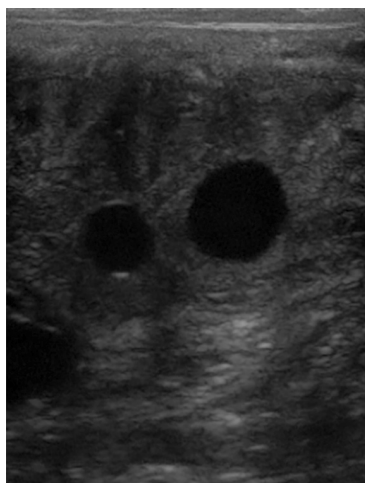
Early detection of twin pregnancy: transrectal ultrasound image showing two vesicles side by side at 14 days post ovulation. One vesicle measures 16 mm and the other one 14 mm.
